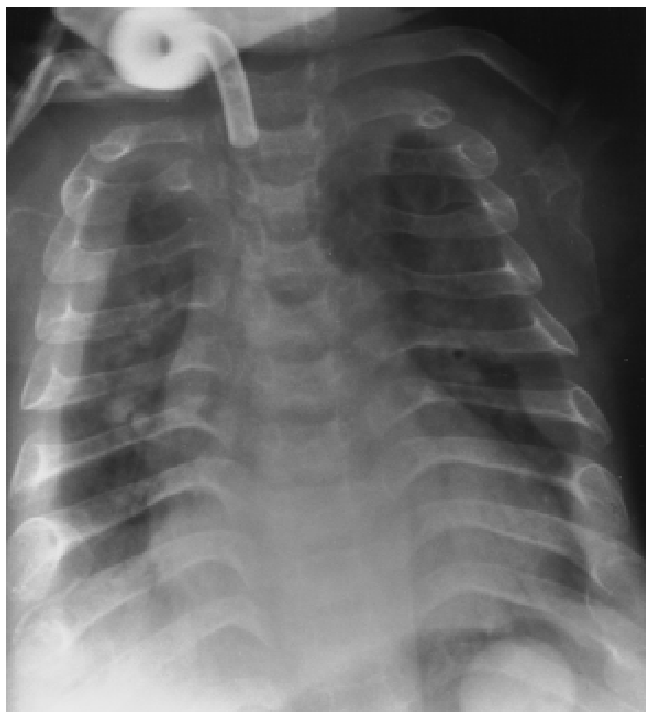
Chest radiograph at 2.9 years. There has been only modest growth of the thorax since birth. Ribs are considerably thicker but remain foreshortened.
